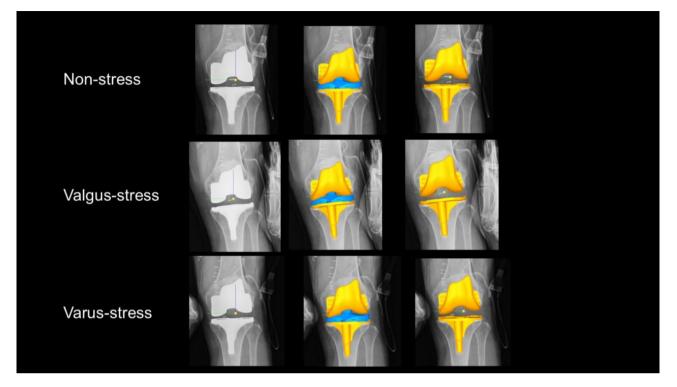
Analysis of femoral component position relative to the tibial component. Left pictures were varus/valgus stress and non-stress x-rays, and central pictures were result of components position after 3D-2D image matching. As result, the position of femoral components was calculated in the coordinate system of the tibial component (right pictures)
